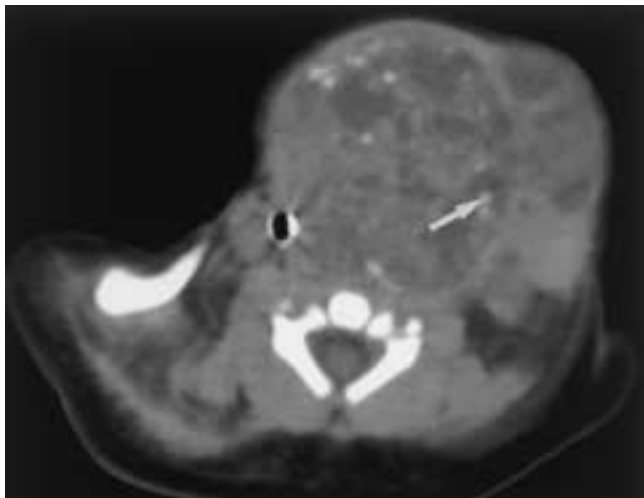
Teratoma in a 1-day-old boy, one of triplets, born with a large neck mass. The baby was intubated at birth. Axial nonenhanced CT demonstrates a heterogeneous solid and cystic tumor containing punctate calcifications (arrow). The endotracheal tube indicates the position of the displaced trachea.
